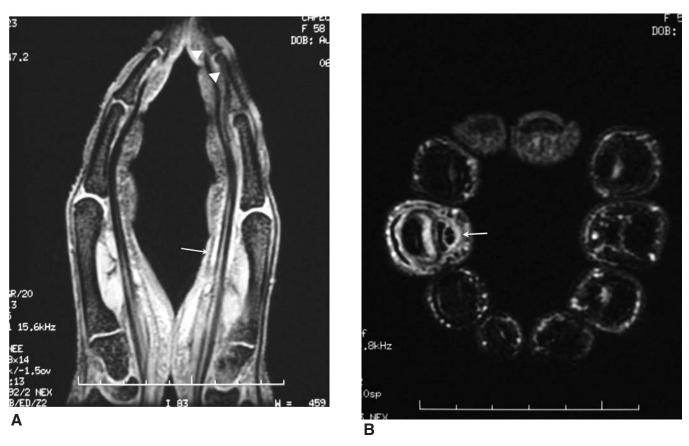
Finger dactylitis. Sagittal gradient-echo T2-weighted (A) and axial fast spin-echo T2-weighted image with fat saturation (B) showing fluid/synovitis in the flexor synovial sheaths (arrows), subcutaneous edema extending all around the circumference, and normal flexor and adjacent bone (arrowheads).
